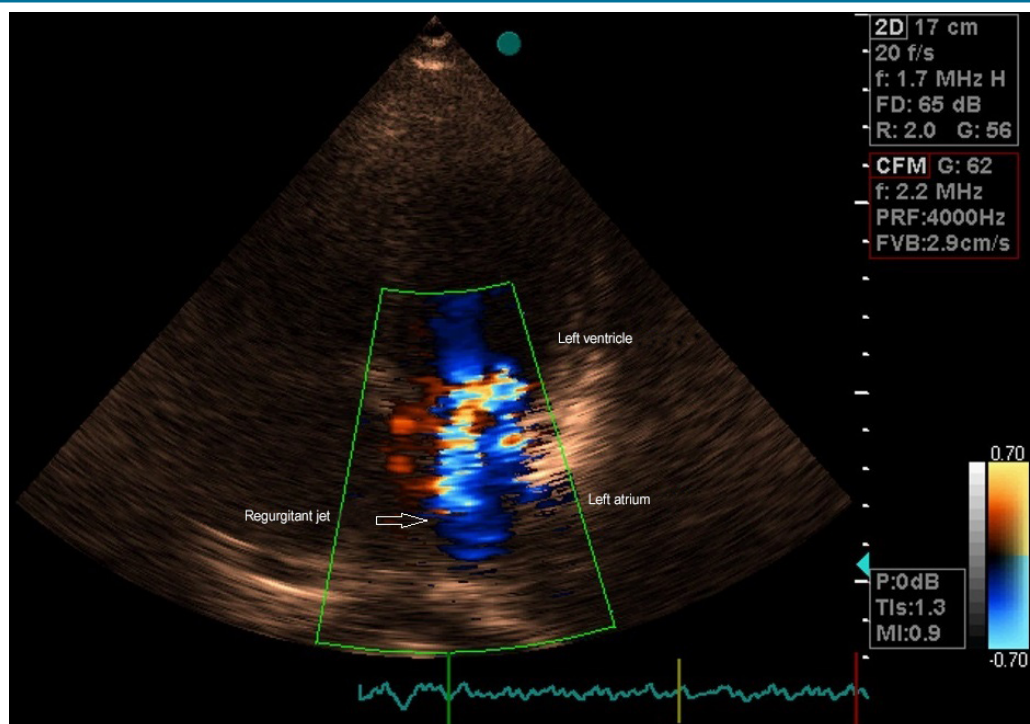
Initial color echocardiogram showing severe mitral regurgitation (maximum area greater than 8 cm²).
